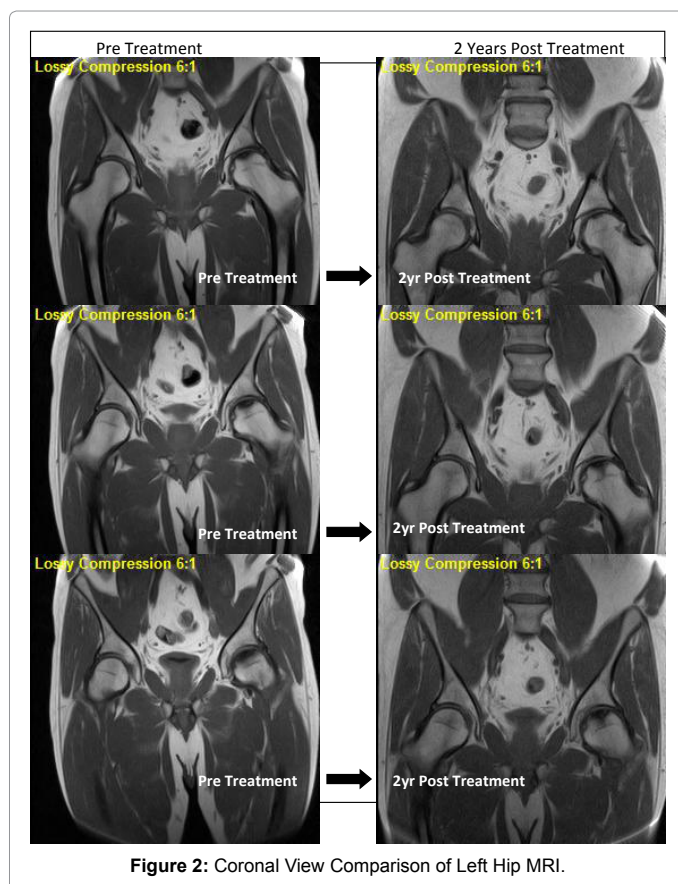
Coronal View Comparison of Left Hip MRI.
